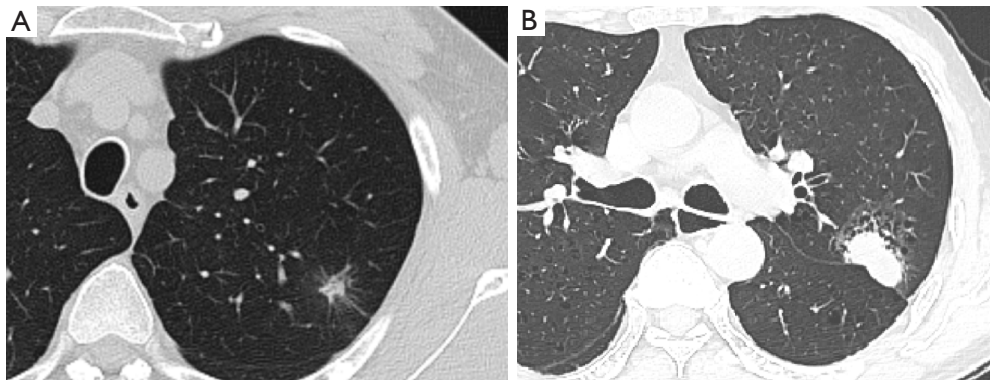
Cases of image evaluation. (A) Image from a 58-year-old male patient with lung adenocarcinoma, with the pathological results indicating no lymph node metastasis. The axial CT scans show an irregular part-solid nodule (long diameter of 19 mm, short diameter of 15 mm) located in the left upper lung. The nodule has superficial lobulation and spiculation at the margin and is pulling the pleura without indentation. A total of 20 negative lymph nodes were detected during the operation, including 2 at stations 2–4, 4 at stations 5–6, 1 at stations 7–9, and 13 at stations 10–14. (B) Image from a 67-year-old male patient with lung adenocarcinoma, with pathological results indicating lymph node metastasis. The axial CT scans show an irregular part-solid nodule (long diameter of 42 mm, short diameter of 34 mm) located in the left upper lung directly in contact with the interlobar fissure pleura; the patient also had emphysema. A total of 30 lymph nodes were detected during the operation (7 at stations 2–4, 5 at stations 7–9, and 18 at stations 10–14), among which 1 cancerous lymph node was located at stations 2–4. CT, computed tomography.
